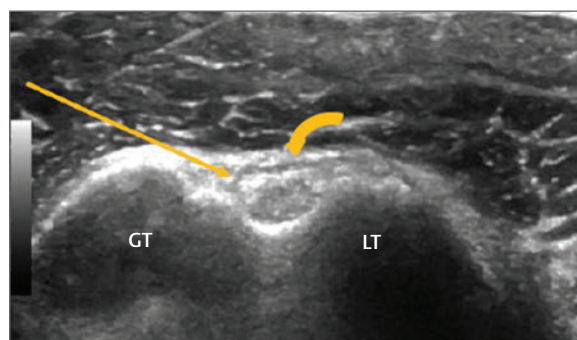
Ultrasound image of the biceps tendon—transverse view. The bicep tendon (B) is seen as an echogenic oval structure lying deep to the transverse ligament (curved arrow). The needle is introduced into the sheath of the tendon from the lateral side (straight arrow). GT, greater tuberosity; LT, lesser tuberosity.
